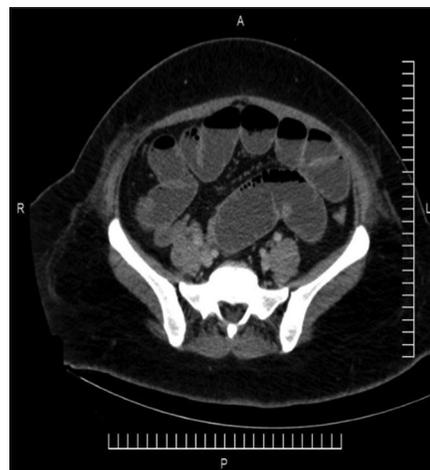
Computed tomography scan suggestive of perforation
